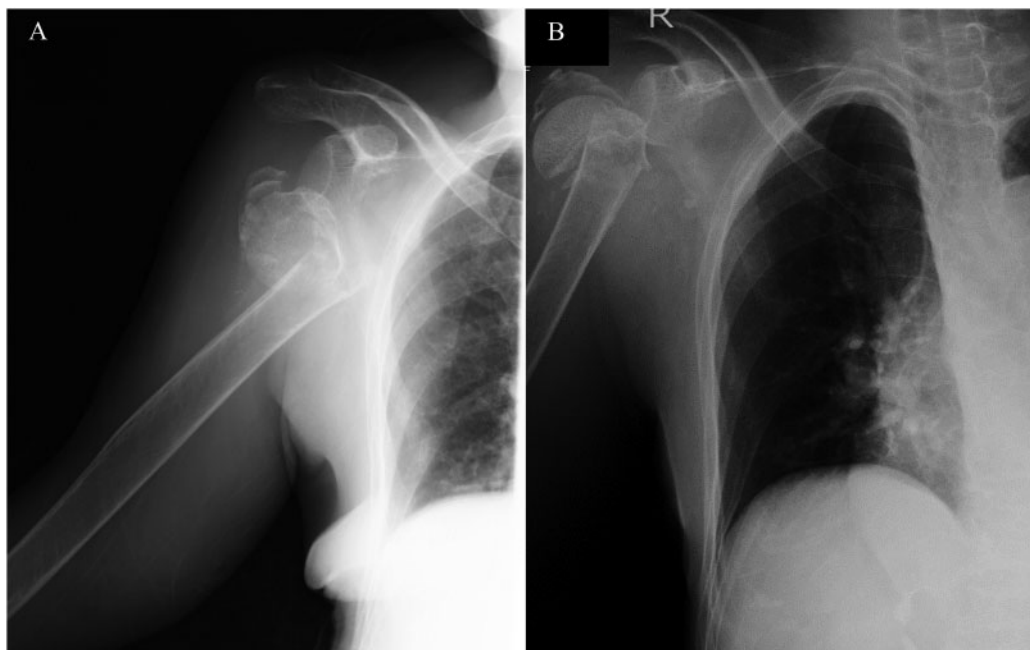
Right shoulder radiograph before (A) and after (B) closed reduction.
